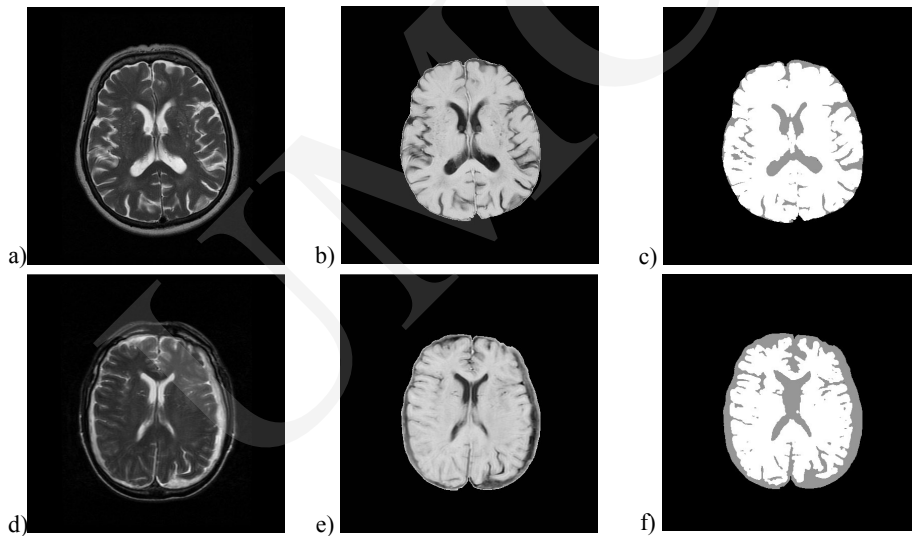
(a, d) the original brain MR image, (b, e) segmented image of forebrain (and inverted original pixels that lie in that region), (c, f) segmented image of white brain matter and gray brain matter
